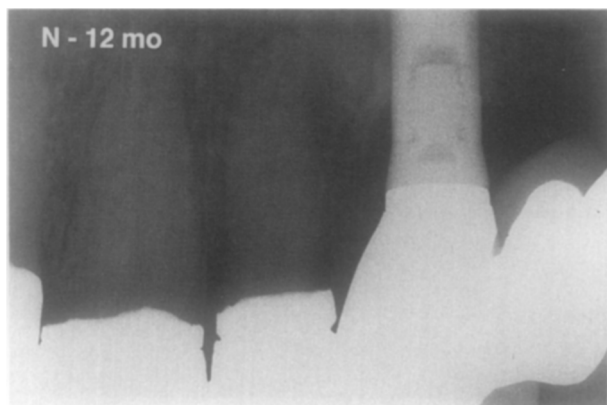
Radiograph at 7 weeks does not show additional improvement (N – 12 months).
